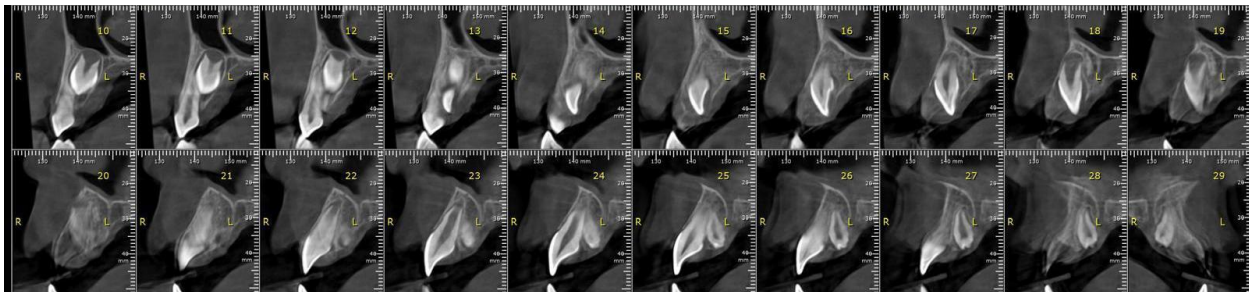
CBCT examination, July 2025, showing the palatal submucosal position of the mesiodens.
